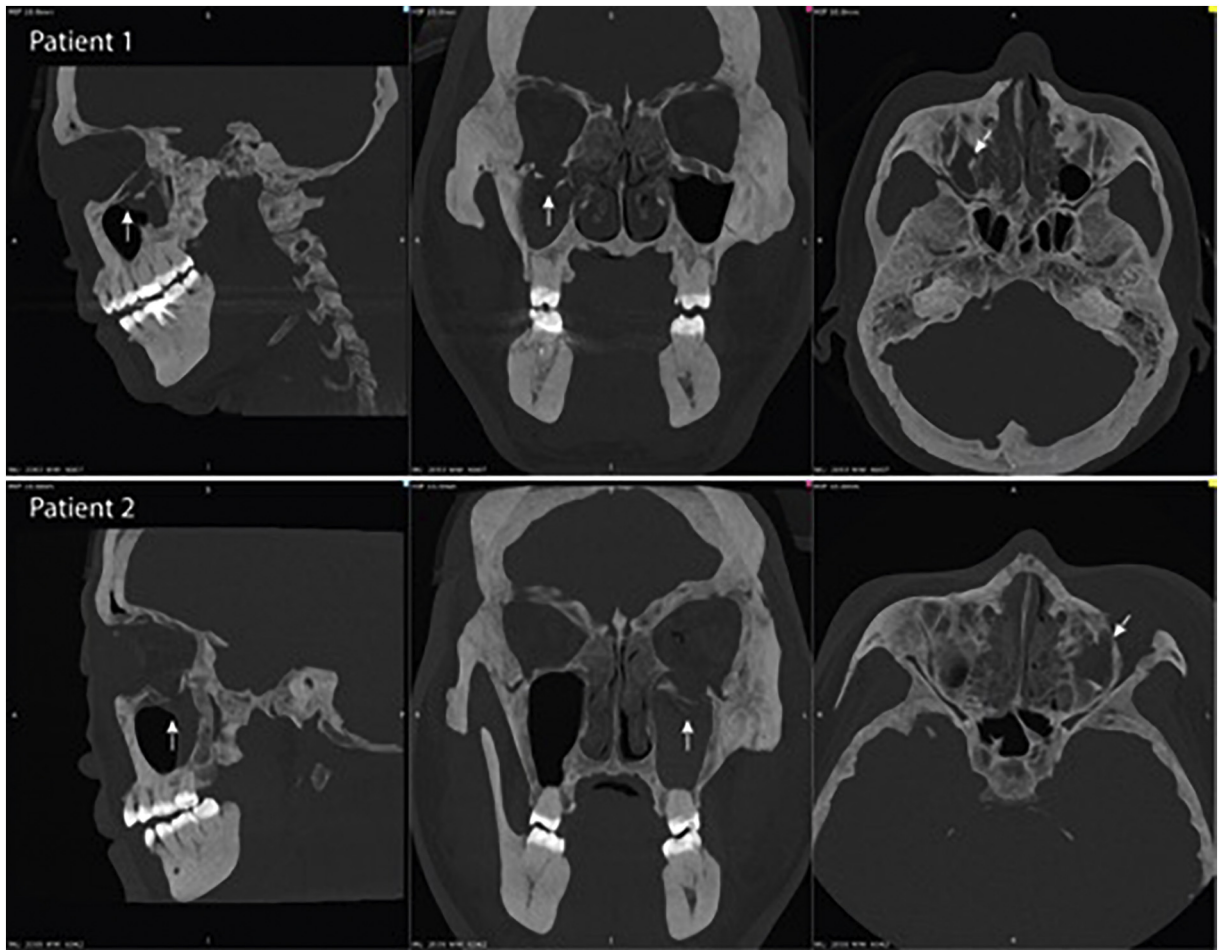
CT scan with 10 mm maximum intensity projection (MIP) views in three planes showing (Patient 1) right sided fractured orbital floor in first patient and (Patient 2) left sided fracture in second patient. Both having caudal herniation of orbital contents.
